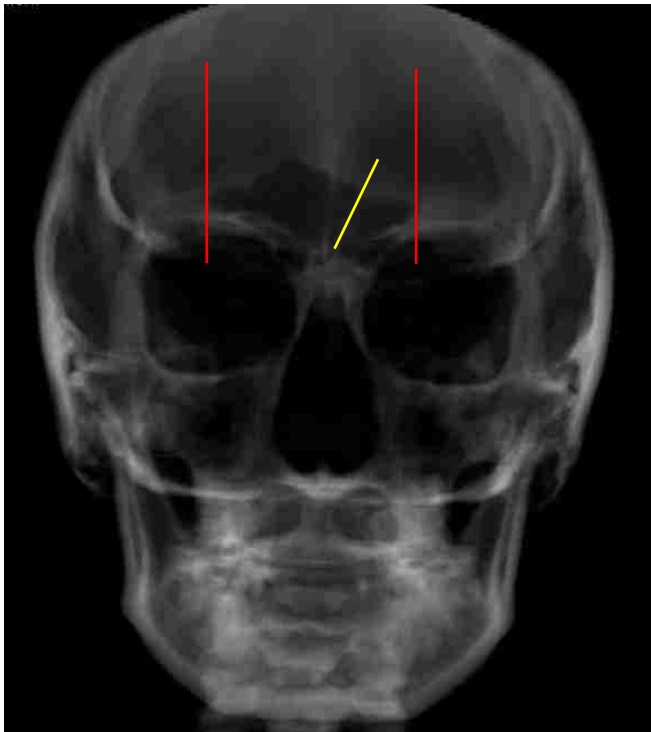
Medial (intersinus septum in yellow) and lateral borders of the frontal sinus from a frontal view (PA radiograph derived from CBCT using Invivo 5.3 Software)
